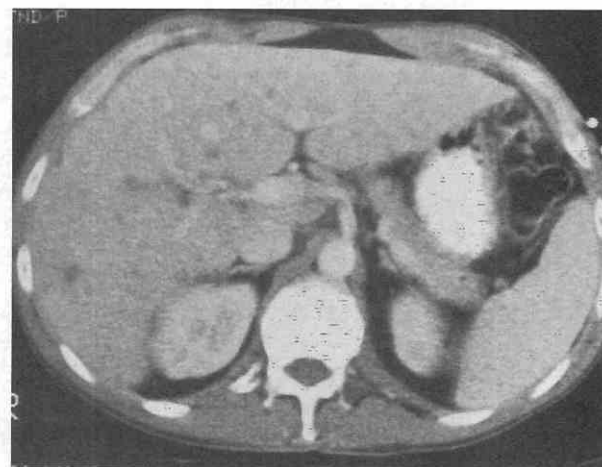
The patient is an immunocompromised man with leukemia and hepatic candidiasis. Contrast-enhanced CT scan demonstrates multiple low-attenuation foci of the liver.
